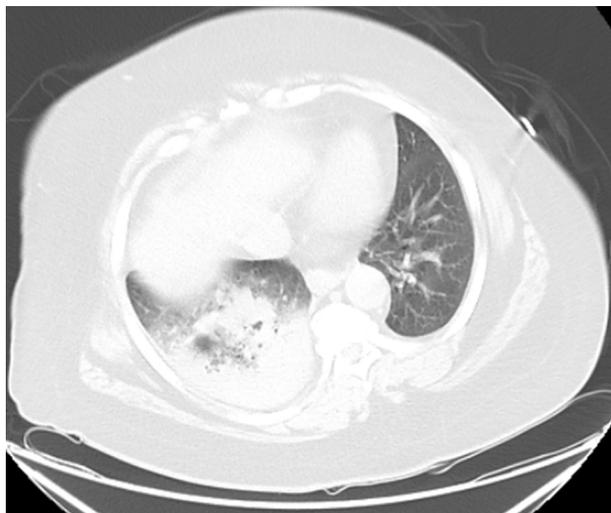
CT chest showing right basilar opacities.
